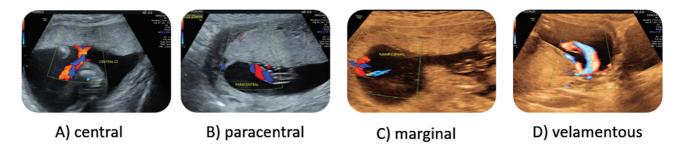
(A–D) Ultrasound images of different types of placental umbilical cord insertion site.
